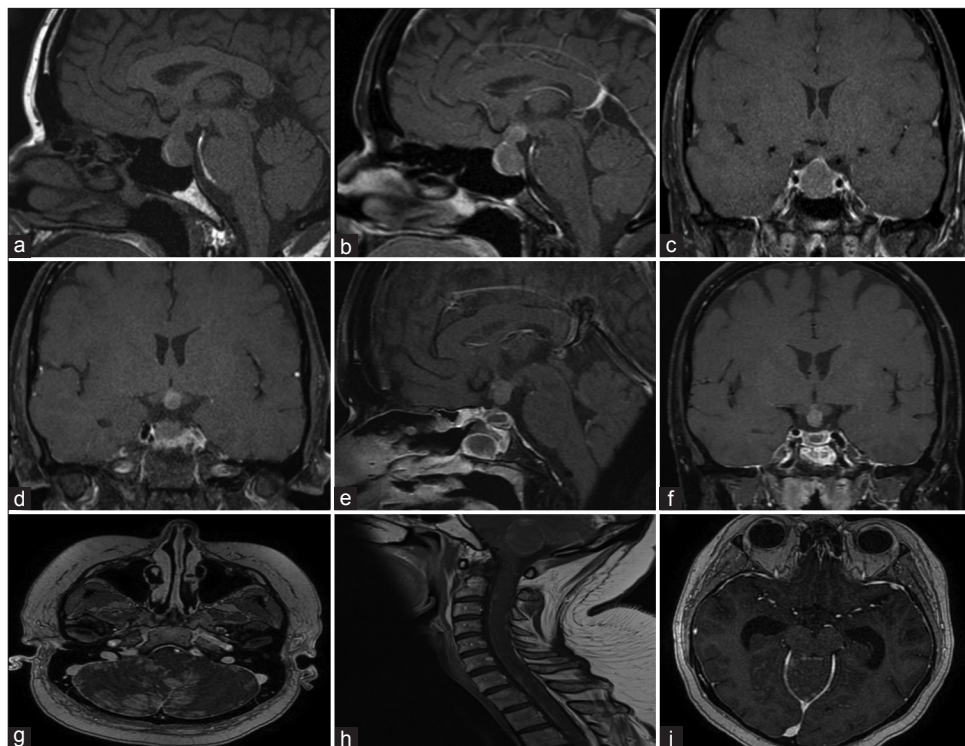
MRI showing PM and. (a-d) Preoperative coronal and sagittal T1 MRI with and without contrast showing a lesion in the pituitary stalk and gland. There is mild splaying of the optic chiasm with lateral displacement of the left optic nerve. (e and f) A residual tumor involving the stalk and hypothalamus was identified on postoperative coronal and sagittal T1 MRI with contrast. (g and h) A follow-up MRI of the brain and cervical spine with contrast showed a leptomeningeal metastatic disease. (i) A follow-up MRI of the brain with contrast showing hydrocephalus due to leptomeningeal disease. A palliative ventriculoperitoneal shunt was placed.
